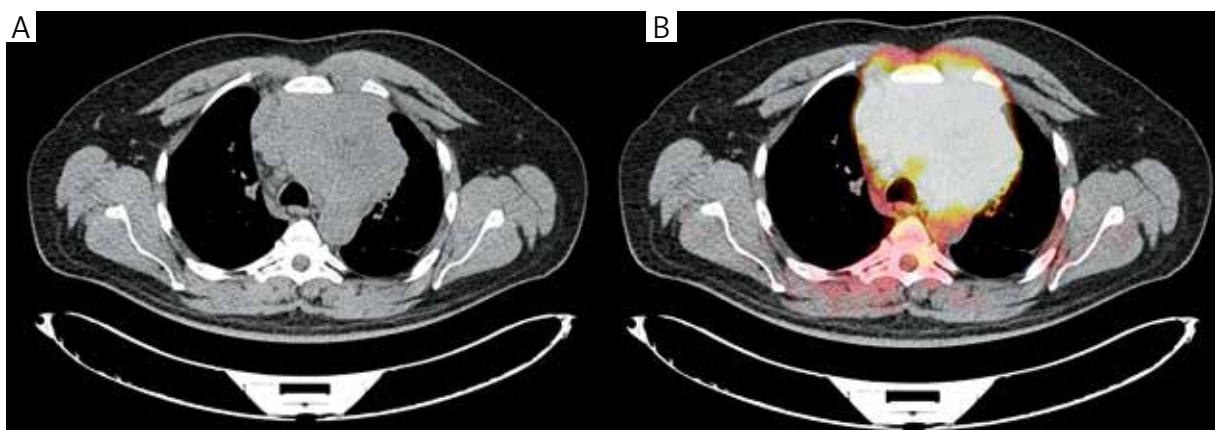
CE-CT and PET/CT scan of a patient with PMBCL before the treatment. A bulky mediastinal mass, with extension into the left lung, is visible
